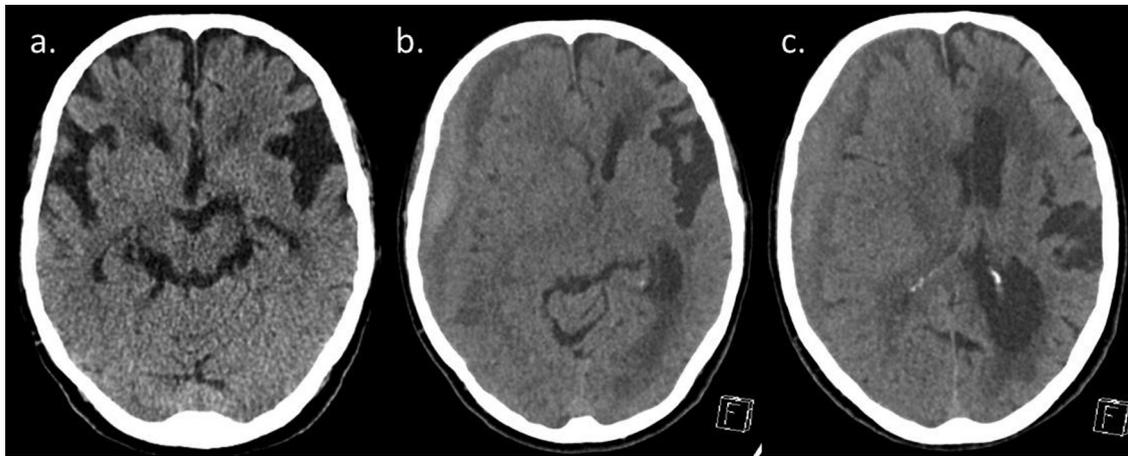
a: brain CT scan was performed three months before ECT; b and c: right chronic subdural hematoma associated with an acute bleeding. The brain shift was about 10 mm.
